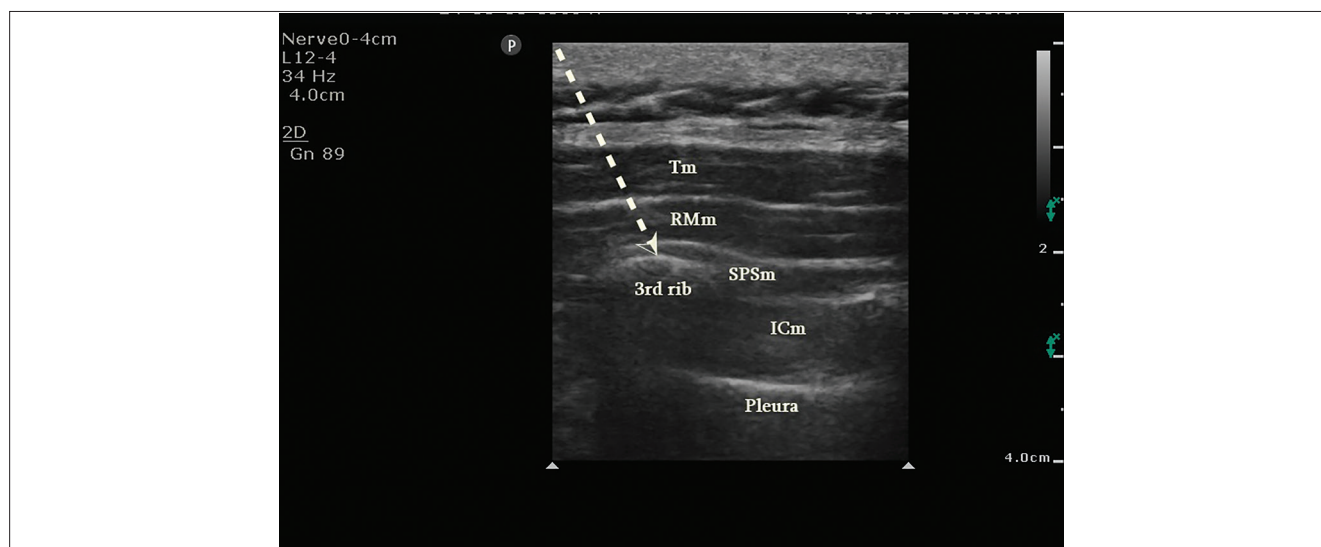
Sonographic visualization of SPSIPB. The Trapezius, rhomboid major, serratus posterior superior, the third rib, and the pleura are visualized. The arrow indicates the needle trajectory. The tip of the arrow is located between SPSm and the third rib.
